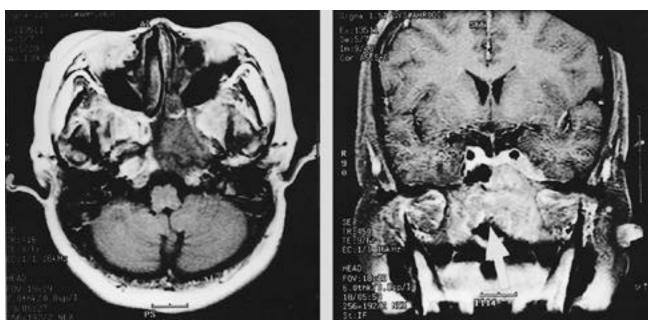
Magnetic resonance imaging of nasopharynx shows mass lesion in right posterior lateral wall of nasopharynx and enlargement of lymph node along bilateral jugular chain (arrow).
